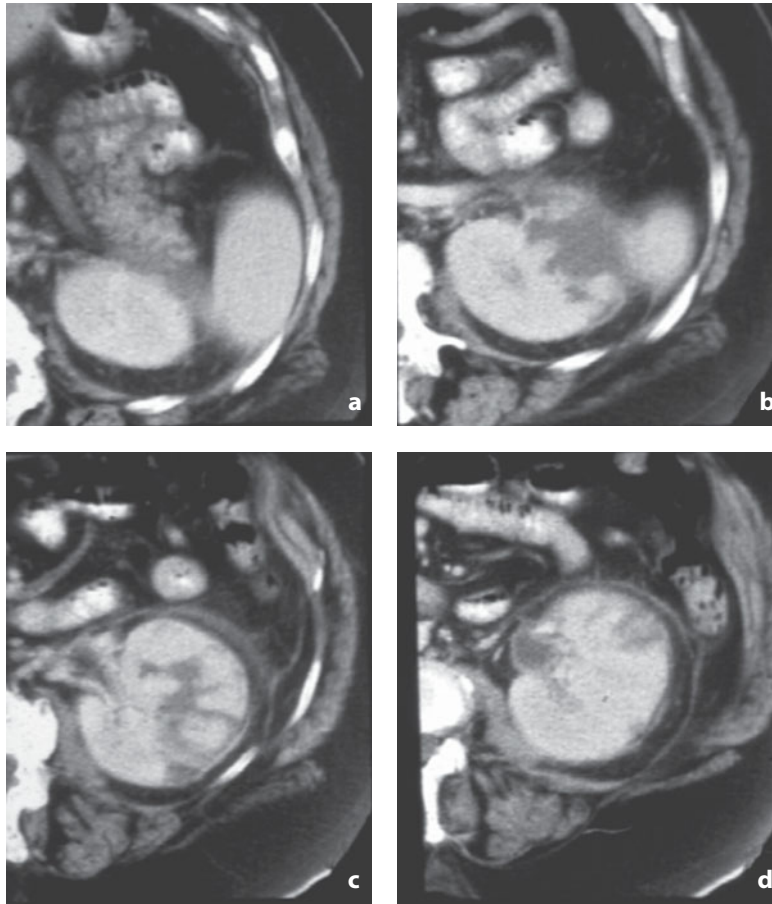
Contrast-enhanced CT. Acute complicated pyelonephritis (diabetic patient). The CT study shows broad hypoattenuating bands indicative of acute pyelonephritis (c, d), complicated by liquefaction and extension into the perirenal space (b). Ill-defined margins of the anterior perirenal fat can also be seen (a, b). The images also show thickening of the anterior renal fascia (c, d) and thickening of the wall of the renal pelvis (d)
